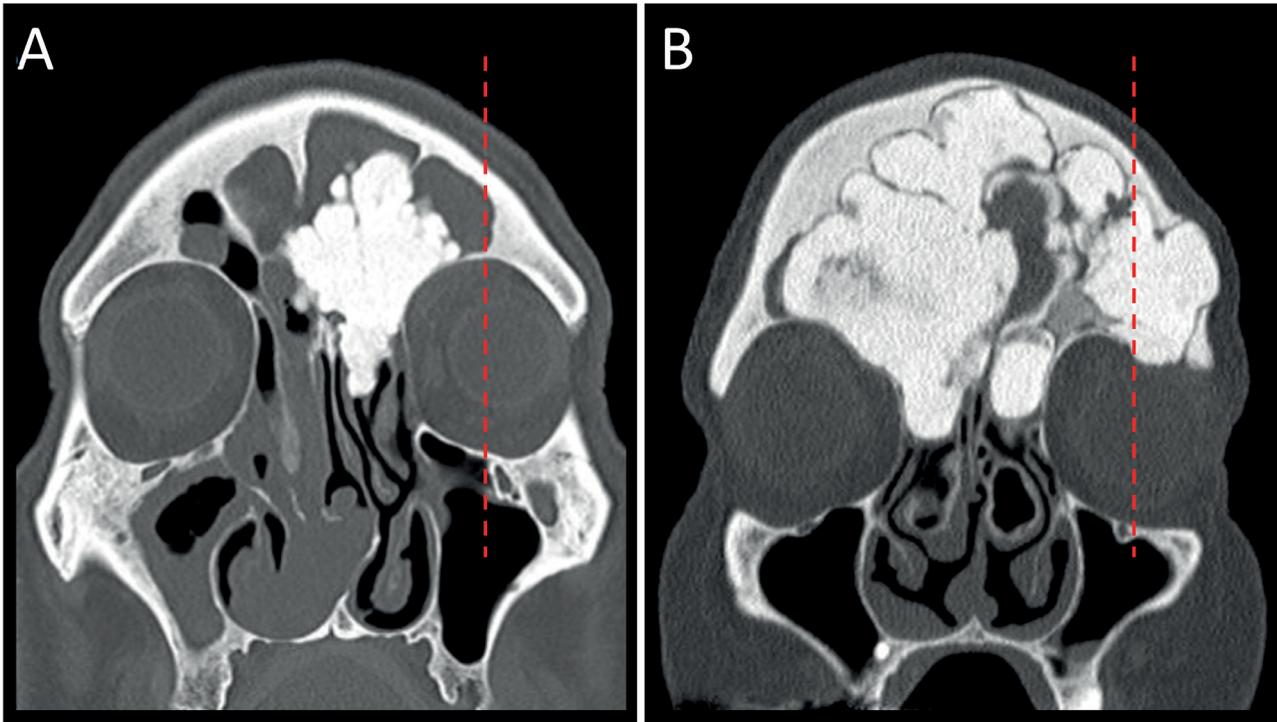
Coronal CT scan showing the medio-lateral extension of frontal sinus osteomas with respect to the meridian of the orbit (red dotted line). Images A and B depict a medial and a lateral osteoma, respectively.
